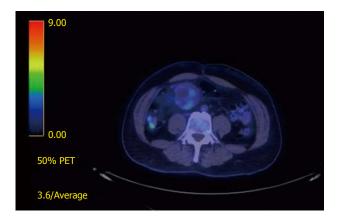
¹⁸Fluoro-deoxyglucose-positron emission tomography scan views of a small bowel gastrointestinal stromal tumors. There is a mildly fluoro-deoxyglucose avid mass adjacent to the jejunal anastomosis with SUVmax 3.4 suggestive of a local recurrence.
